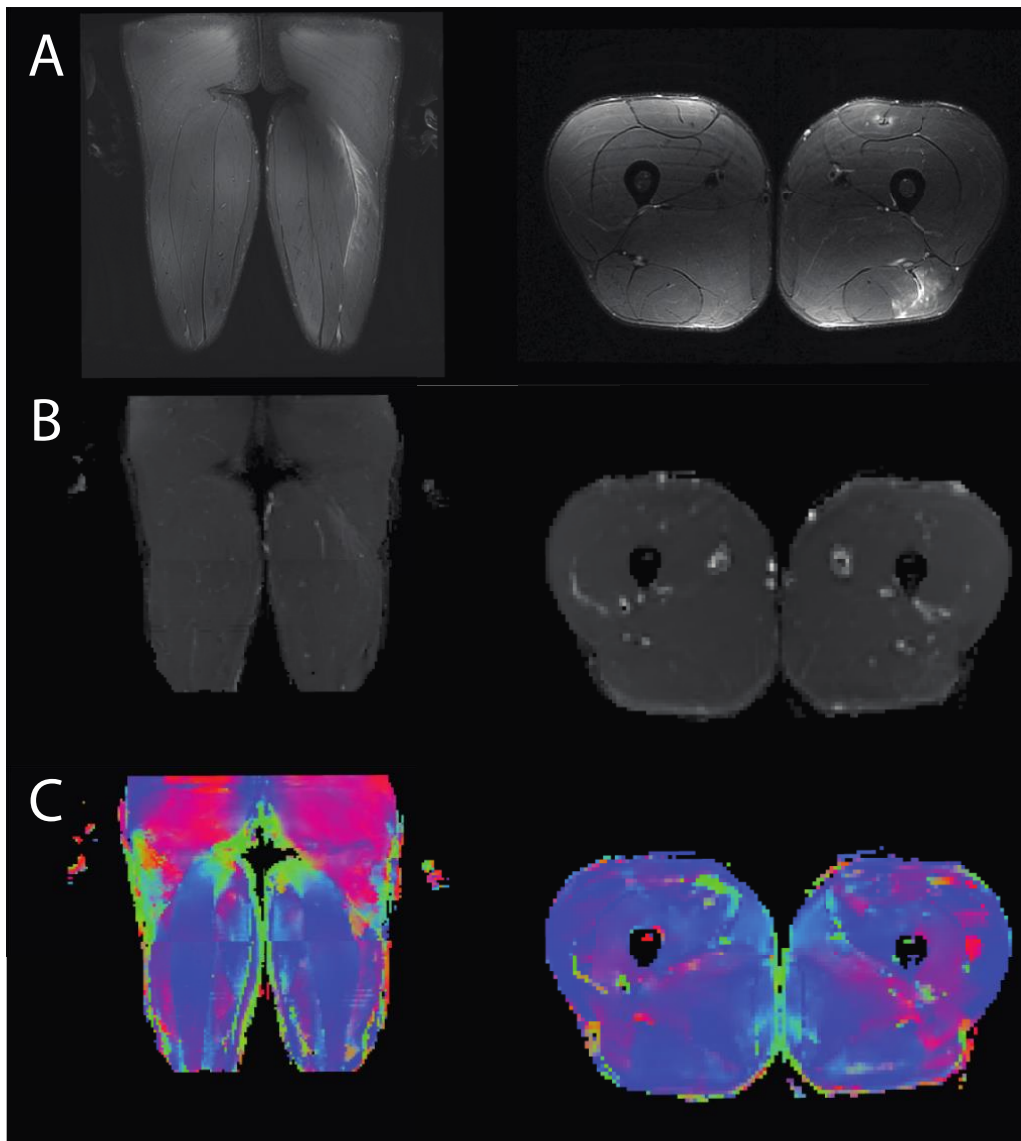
Representative imaging data from one participant at return to sport, A.) T2-weighted, B.) mean diffusivity, and C.) primary eigenvalue maps along principal direction.
